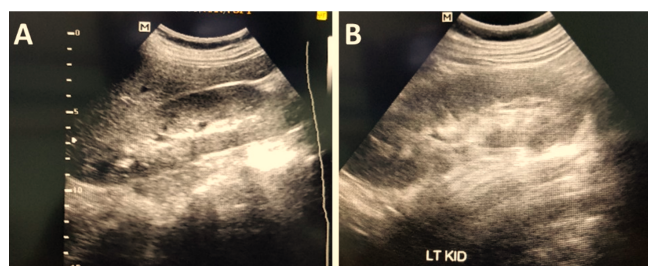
Ultrasound of the kidneys of the pregnant woman at the 25th week of gestation. A: Right kidney ultrasound confirms the complete resolution of the perinephric fluid collection. B: Left kidney ultrasound proves the full resolution of the perinephric fluid collection.
